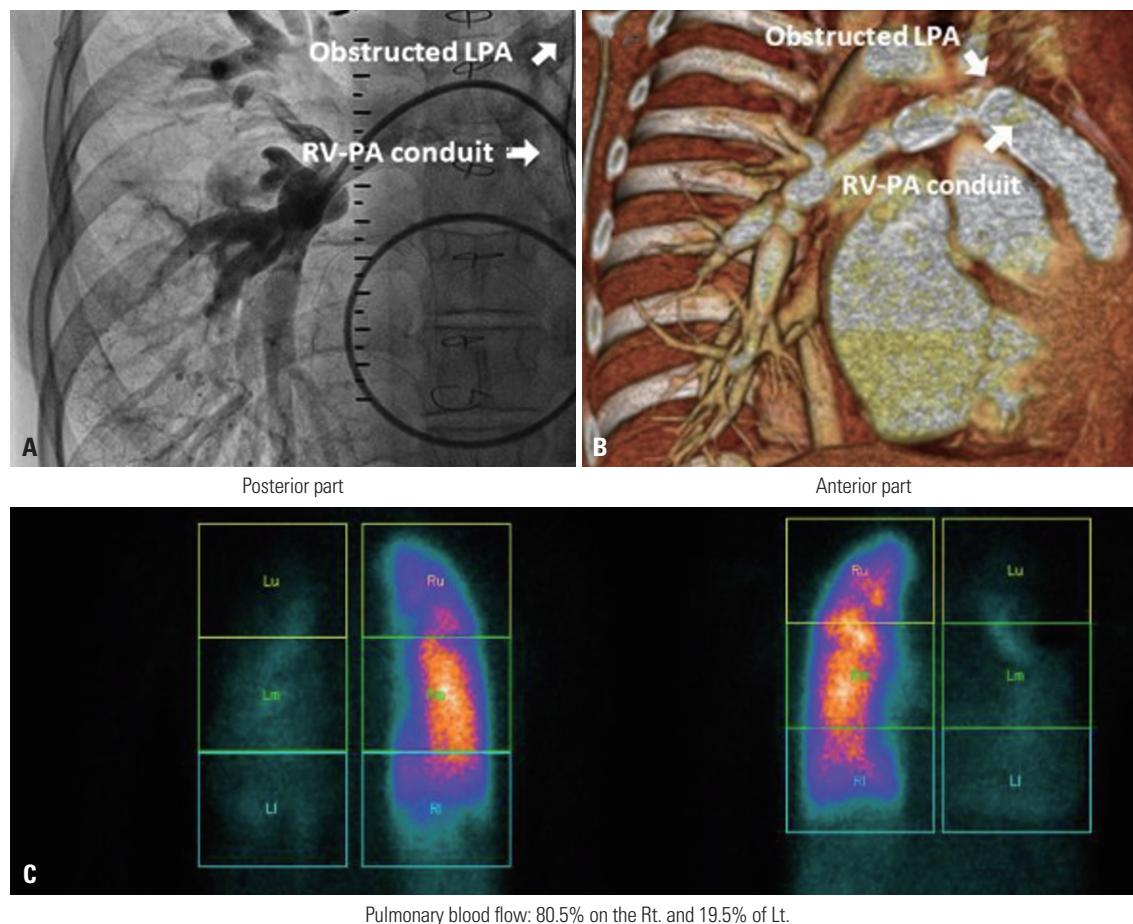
Pulmonary angiogram (A) and computed tomography scan (B) revealed obstruction of the left pulmonary artery and right pulmonary artery with peripheral stenosis. Lung perfusion scan before transplantation (C) showed the patient's physiologic single lung status. LPA, left pulmonary artery; RV-PA, right ventricle to pulmonary artery.
